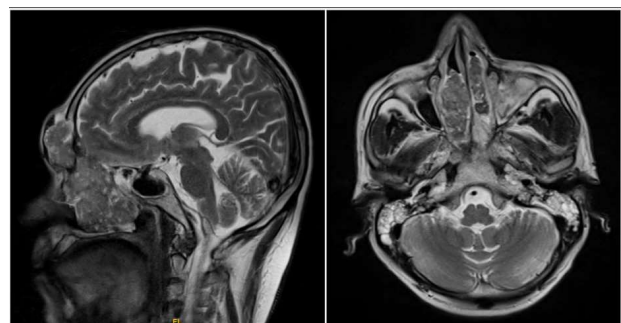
MRI face + Neck with contrast showing lesion involving bilateral nasal cavities, ethmoid air cells, protruding posteriorly into the nasopharynx and anteroposteriorly extending into the right frontal sinuses
